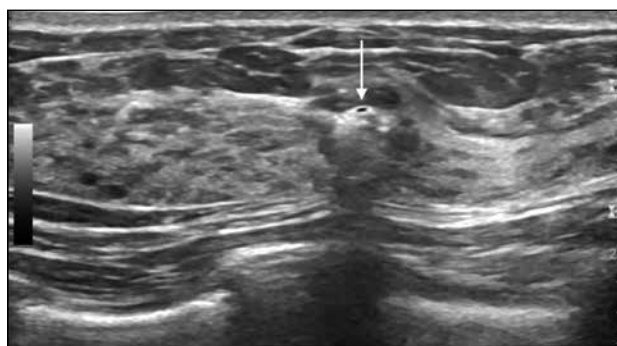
Perpendicular transverse ultrasonography shows the biopsy needle (arrow) within the targeted lesion, indicating satisfactory positioning.
